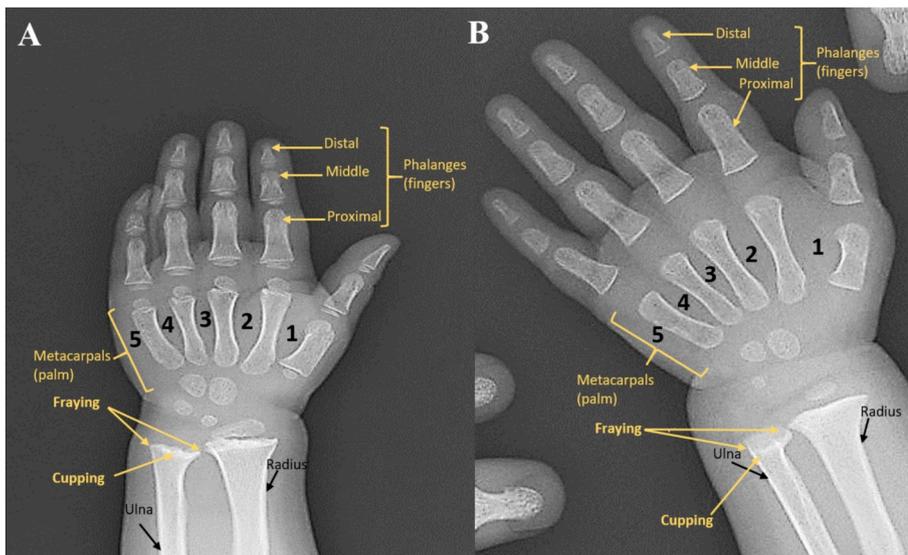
Skeleton characteristics of phalanges (fingers), especially the metacarpals, ulna and the radial bone of the Schmid Metaphyseal Chondrodysplasia (SMCD)-affected female child and the younger male sibling by radiograph imaging. A and B, A normal skeleton features of the distal, middle, proximal and metacarpals (palm) of the SMCD-affected female child and the male sibling; cupping and fraying of the distal metaphyseal ulna bone edges of the SMCD-affected female child (A) and the male sibling (B).
